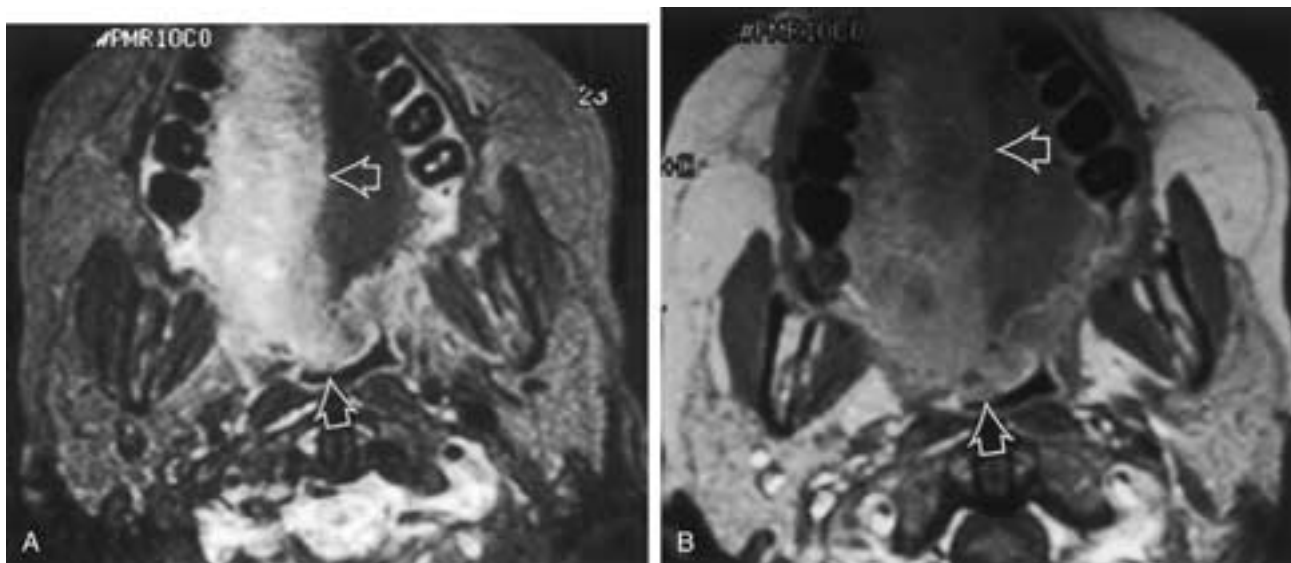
Acute hypoglossal nerve denervation. (A) Axial T2-weighted and (B) axial T1-weighted images with contrast enhancement and fat suppression reveal edema-like increased signal intensity in the right hemitongue on A that demonstrates enhancement (B). Note the protrusion of the hemitongue across the midline and posteriorly into the oropharynx (arrows).
